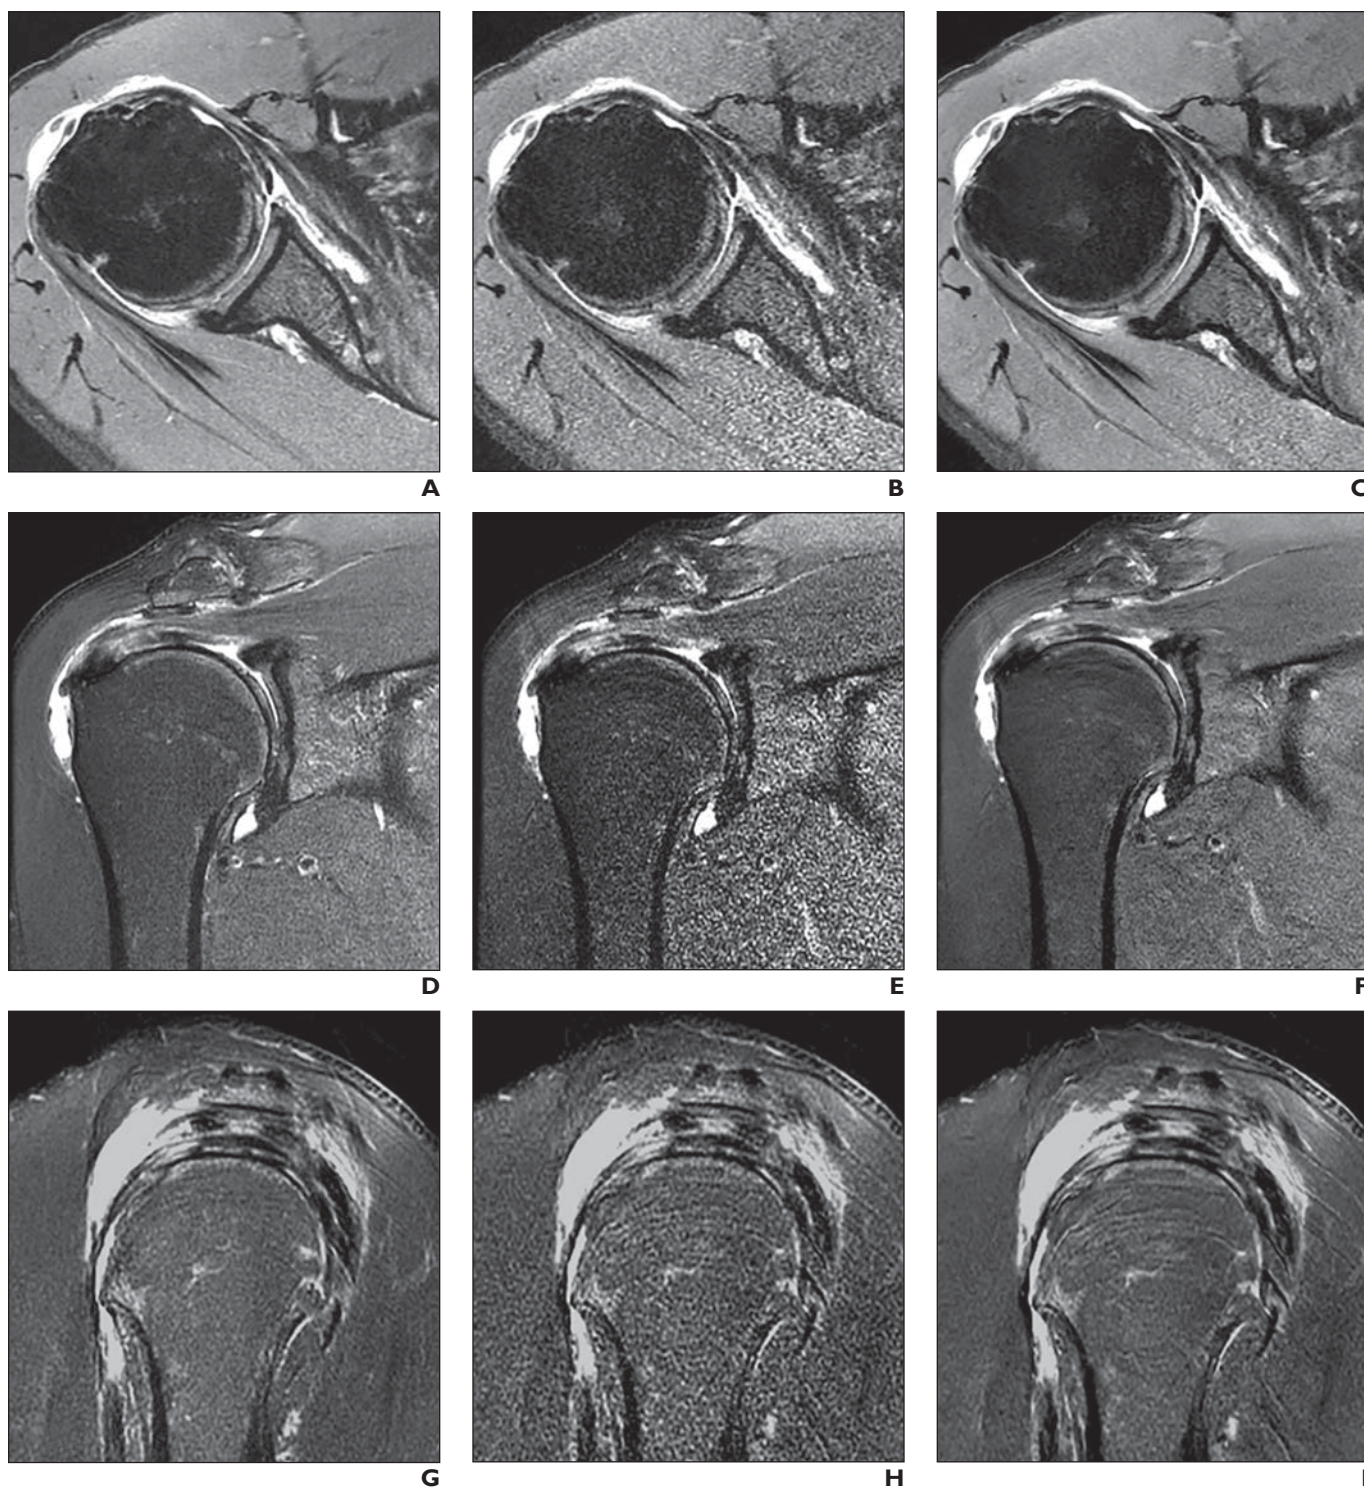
61-year-old man with right shoulder pain who underwent MRI.
